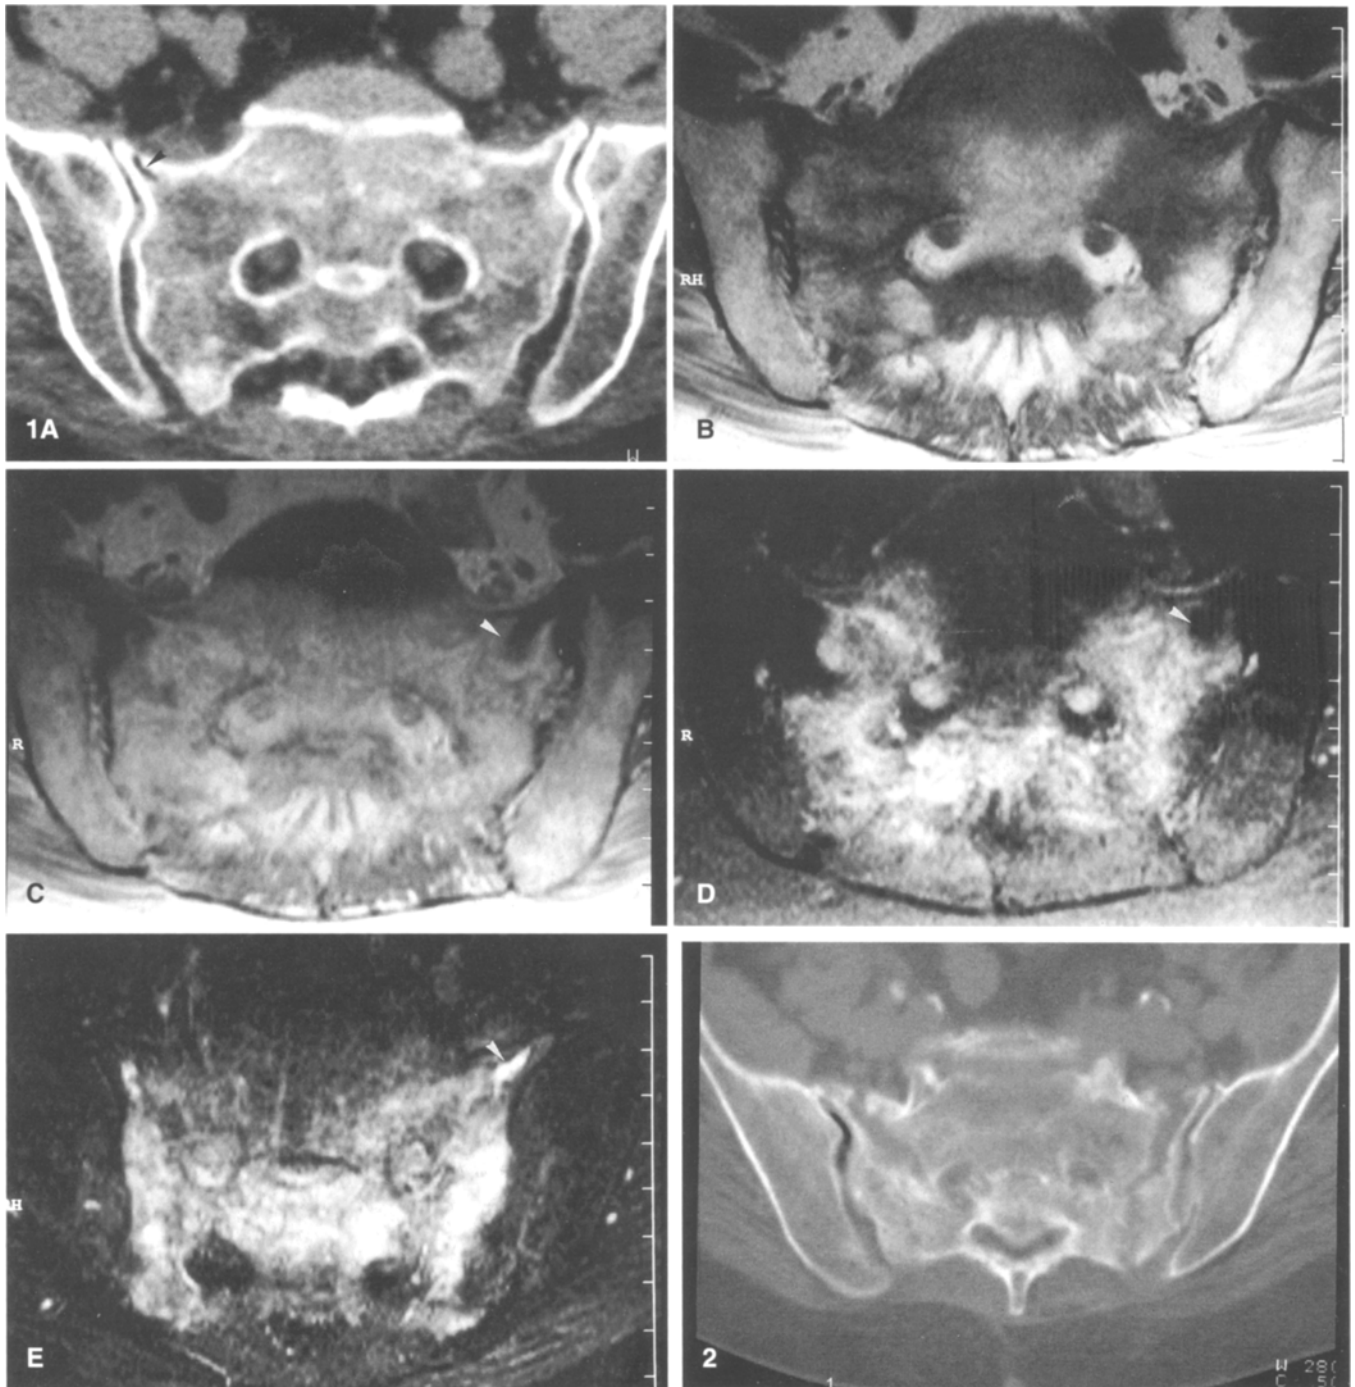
A Computed tomography (CT) scan shows vacuum phenomenon in the ventral part of the right sacral bone with irregular sclerosis of the lateral masses. B T1-weighted magnetic resonance (MR) image (570/15 ms) exhibits low-intensity areas in both lateral masses of the sacrum and the central portion between the neural foramina. C After gadopentetate administration enhancement of these areas is shown. D Enhancement is demonstrated to good advantage by the frequency-selective fat-suppressed T1-weighted image (602/15 ms). High-signal areas
